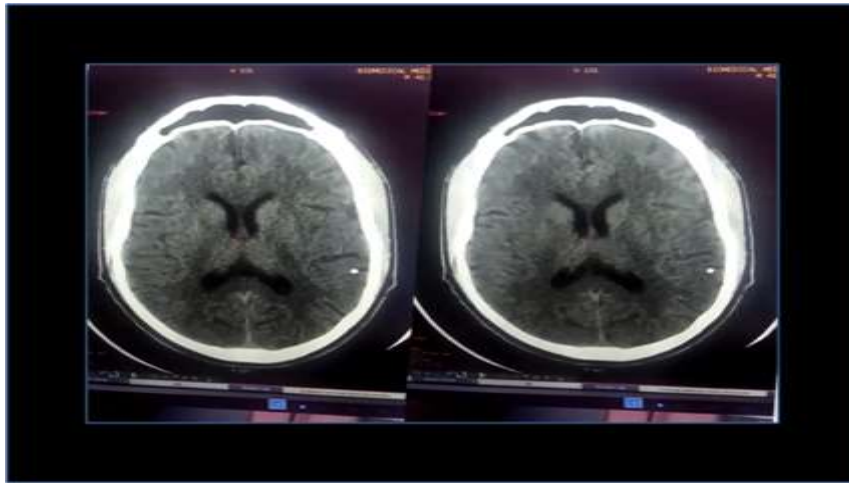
Normal Brain CT of patient at presentation
